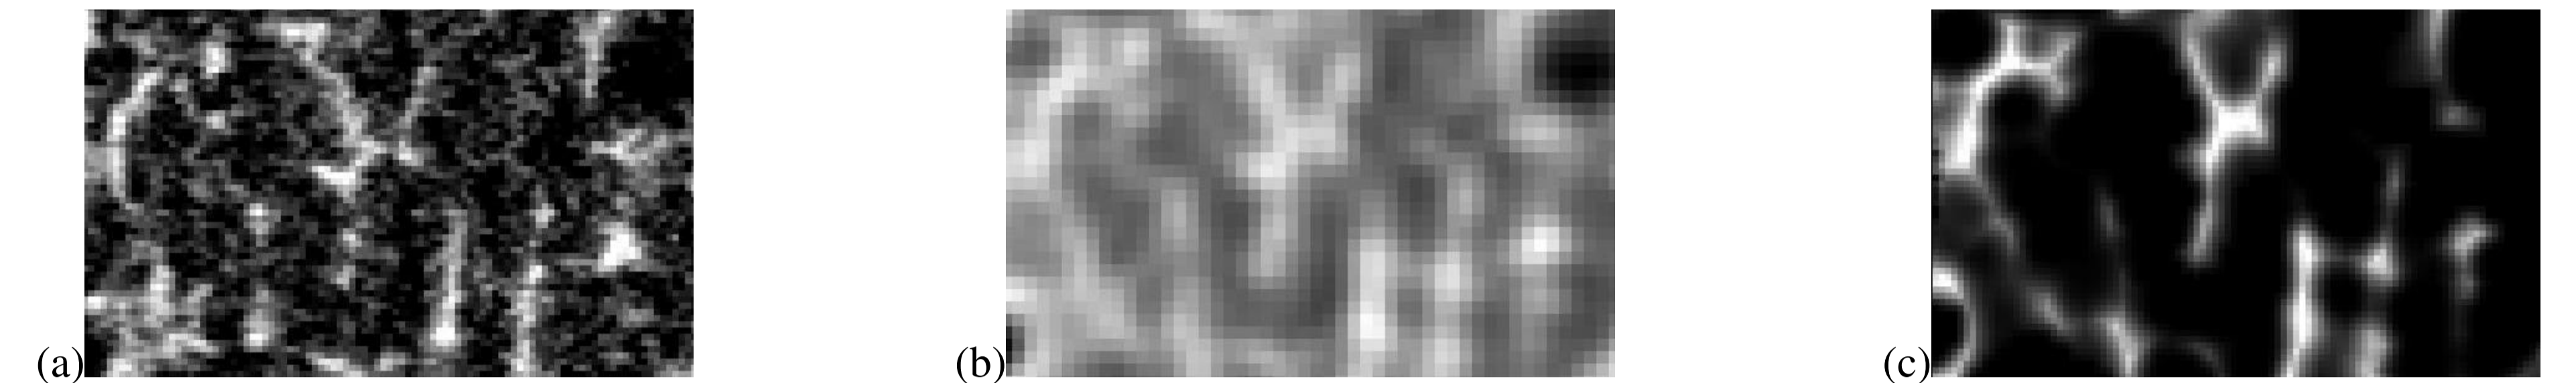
(a) Detail of sagittal cut through a vertebra of Set 2 scanned by XCT. (b) Sampling of this detail to HRCT resolution. (c) FDT of (b).
